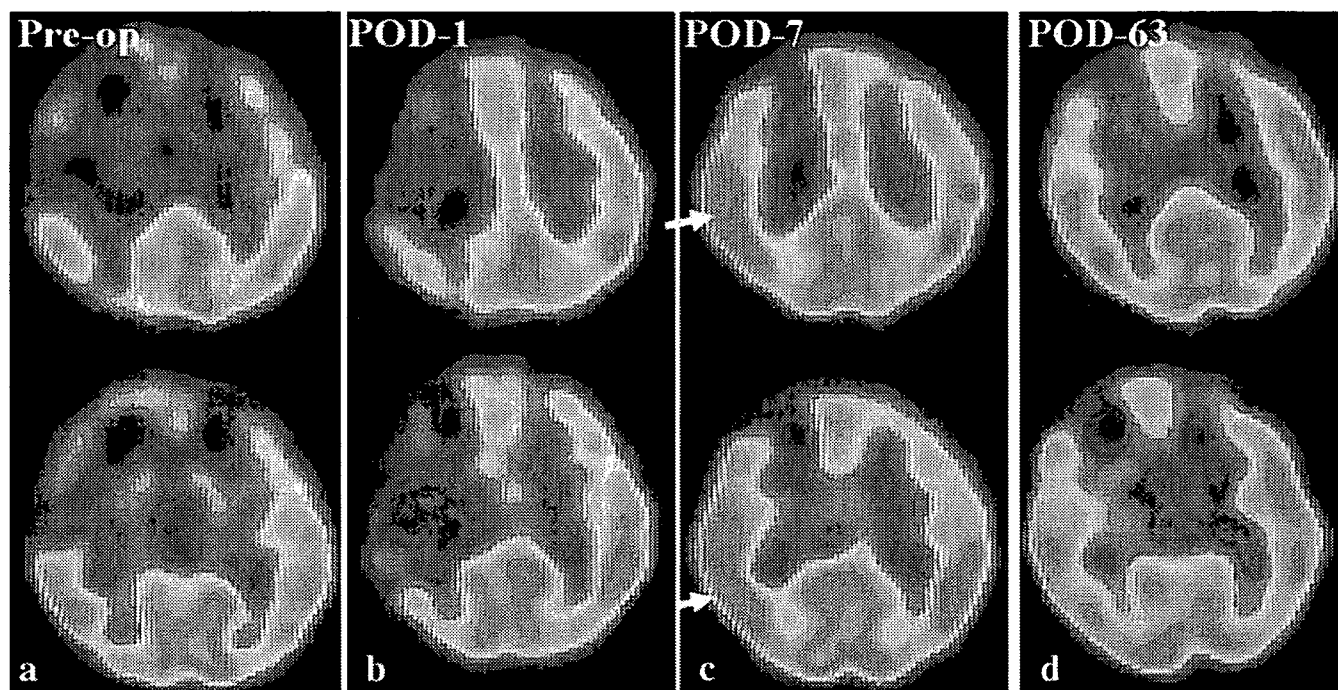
¹²³I-IMP-SPECT scans before surgery (a) and 1 (b), 7 (c), and 63 days (d) after right STA–MCA anastomosis. The focal intense increase in CBF at the site of anastomosis (arrows in c) was evident 7 days after surgery, when the patient suffered left facial palsy. Two
